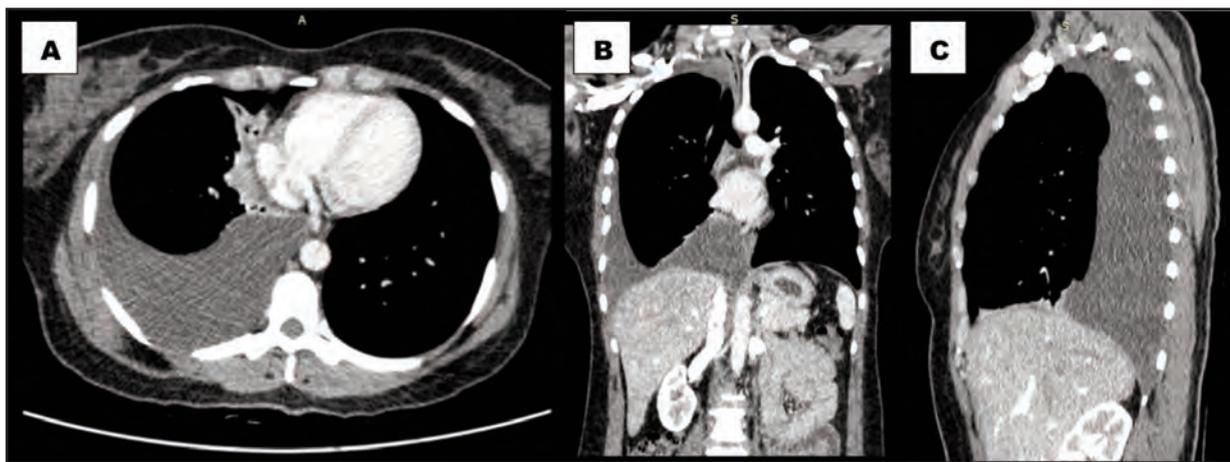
Multi-density right pleural effusion on axial (A), coronal (B) and sagittal (C) cuts of CT Thorax, consistent with right haemothorax
